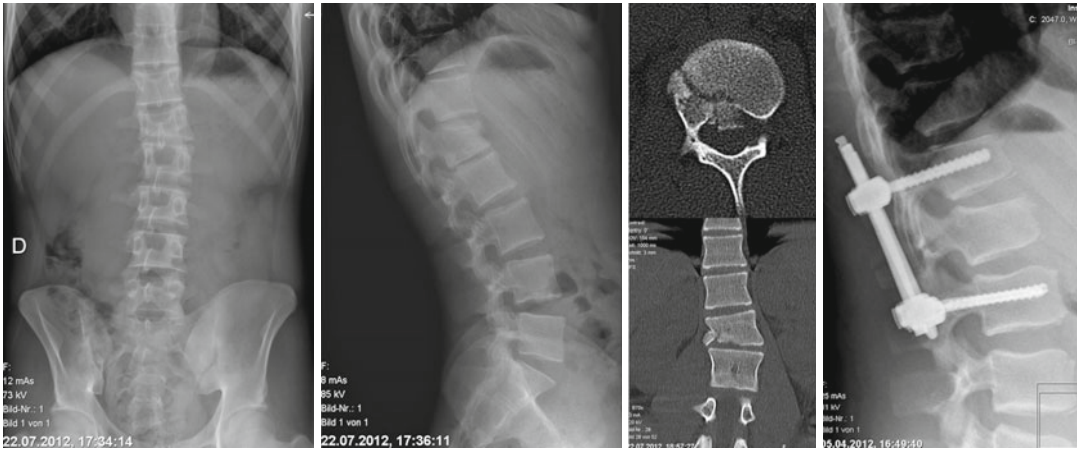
Typical compression fracture in an older child (14 years). CT scan shows the dorsal wall fragment in the spinal canal; fortunately in childhood in 95 % cases there
